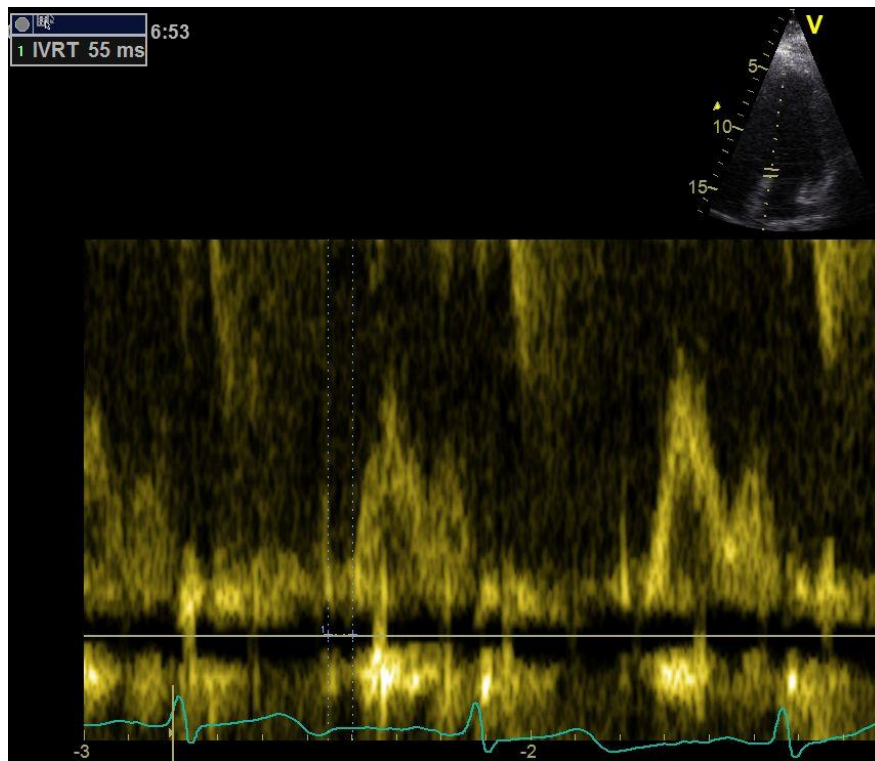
Measurement of IVRT using pulsed wave spectral Doppler image of mitral annulus from apical four chamber view. First picture: 2D image of apical four chamber view which shows the sample volume at mitral annulus; second image: pulsed wave image of mitral annulus.
